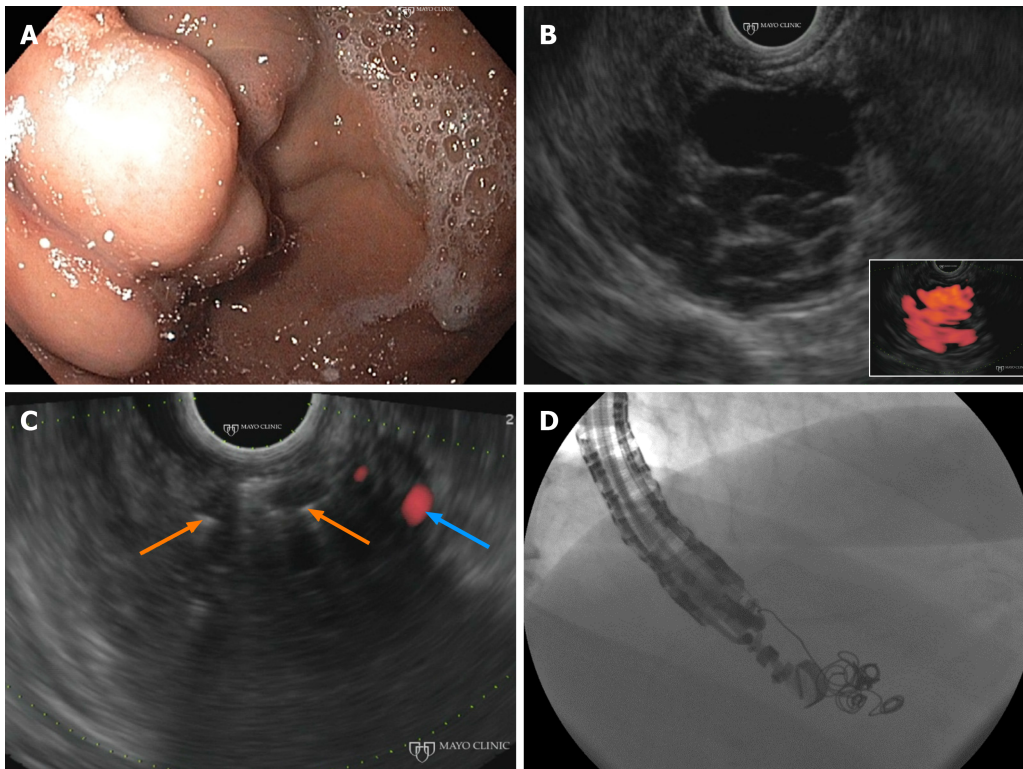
Endoscopic ultrasound-guided management of gastric varices. A: Gastric varices seen on endoscopy. B: Gastric varices appear anechoic on endoscopic ultrasound (EUS) grey-scale and are highlighted red by Doppler study (inset). C: Injection of embolization coils (orange arrows) into the varices results in near complete resolution of blood flow (blue arrow). D: Fluoroscopic visualization of EUS-guided coil embolization.
